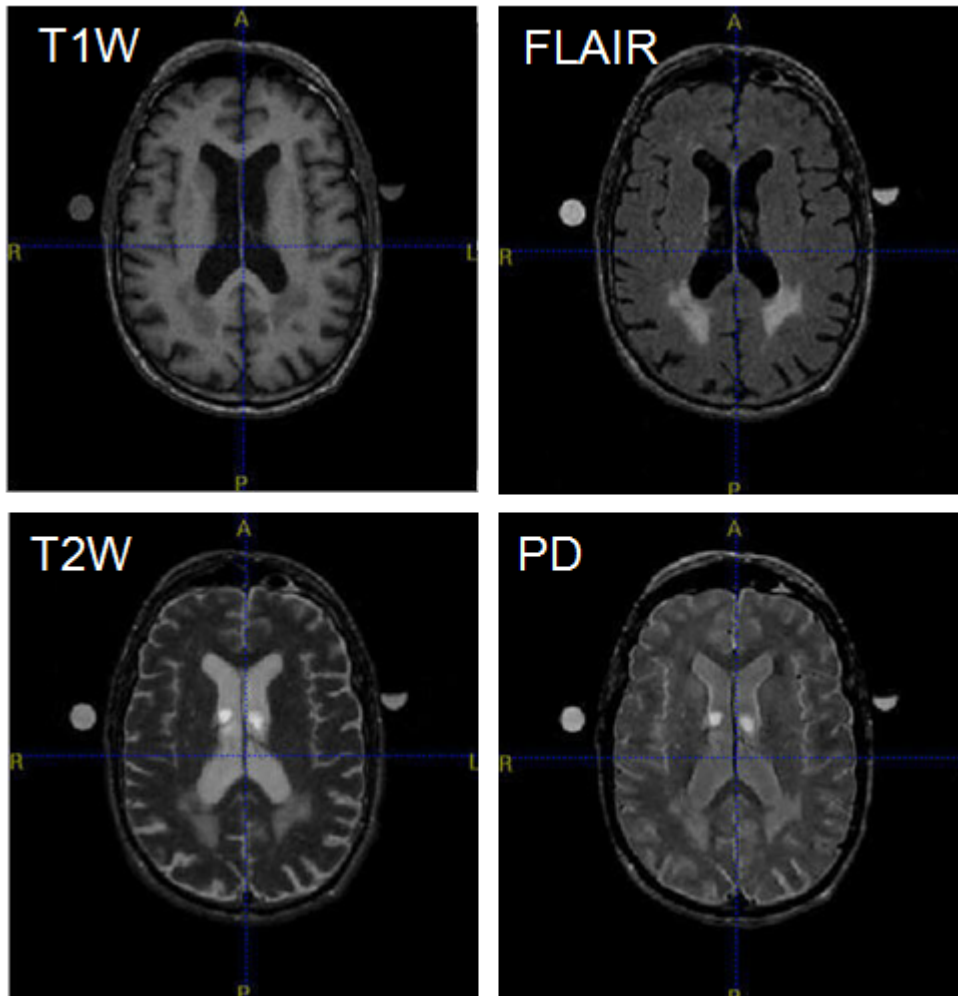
MRI modalities [18]
